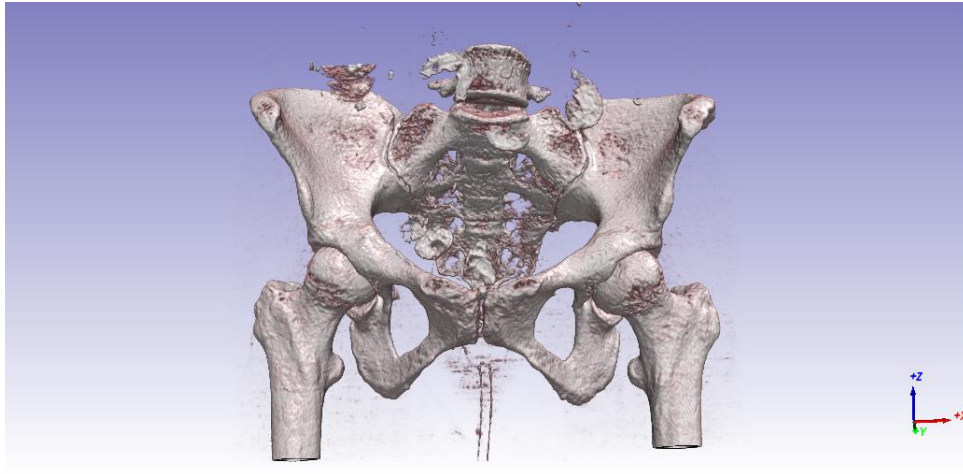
A coronal view of one of the CT scan images used for this study in the Simpleware ScanIP software including just the bone (this was included in the segmentation process which highlighted a pre-set range of the greyscale denoting cortical bone).
